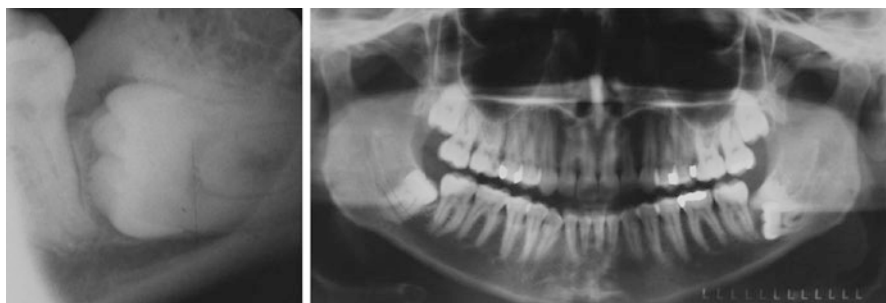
This periapical radiograph does not adequately evaluate the relationship of this impacted tooth to the inferior alveolar nerve or the associated osseous pathology demonstrated in the panorex
